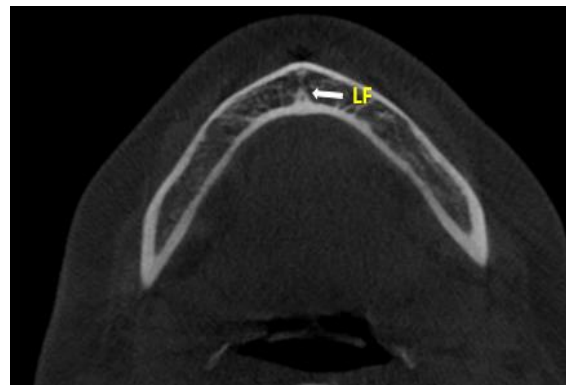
The CBCT axial plane displays the lingual foramen (LF).
